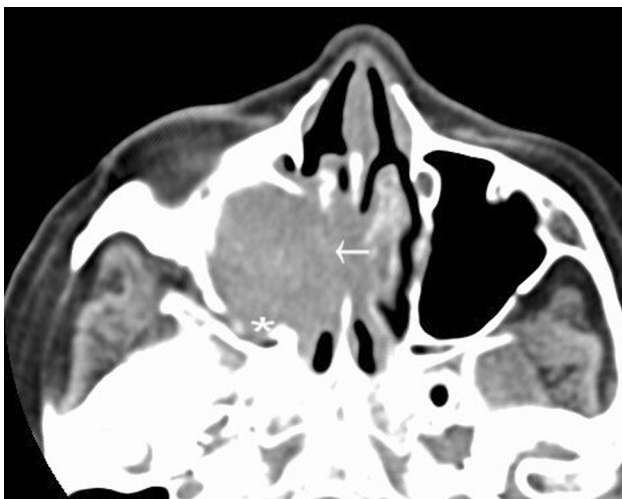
Axial, non-contrast, CT scan demonstrating a complex mass filling the right maxillary sinus with erosion of the medial (*arrow*) and posterior maxillary sinus walls (*asterisk*)
